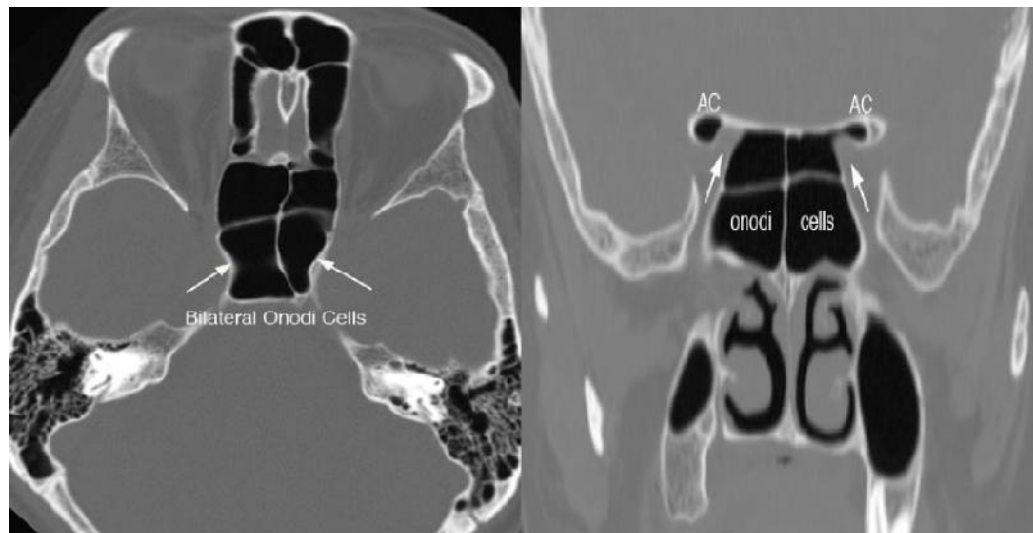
Axial and Coronal CT images showing Onodi Cells
